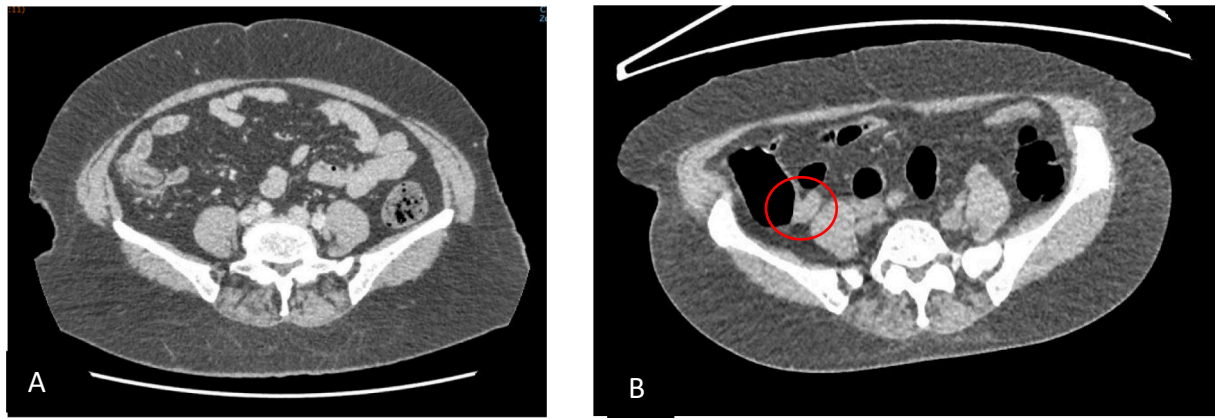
A showing right colona inflammation on CT scan 2 years prior to diagnosis and B showing abnormal appendix from CT pneumocolon circled in red.
